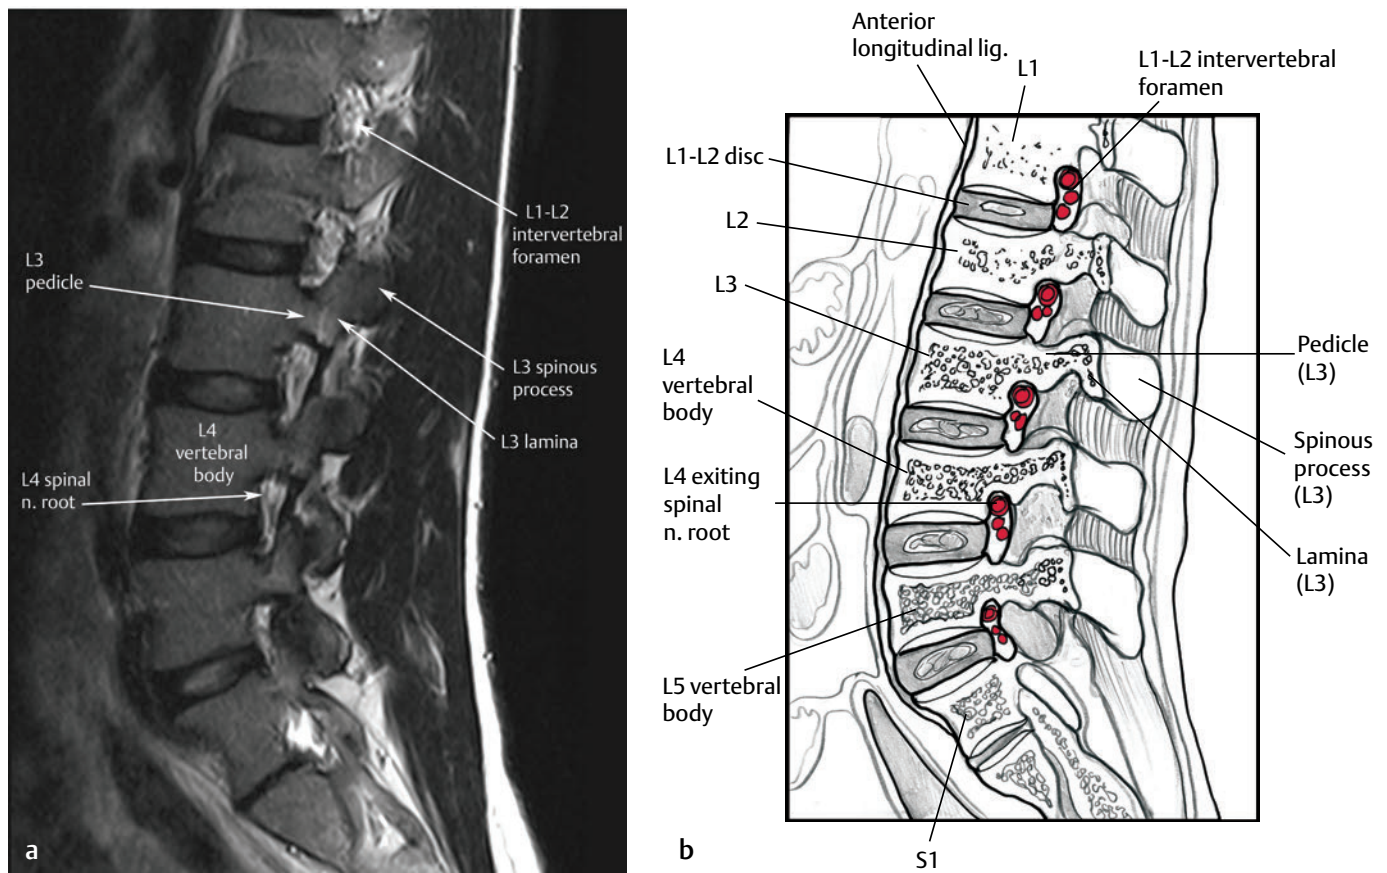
This (a) parasagittal T2-weighted image and (b) artist's sketch of the lumbar spine show the neural foramina and exiting nerve roots at multiple levels.[†]
